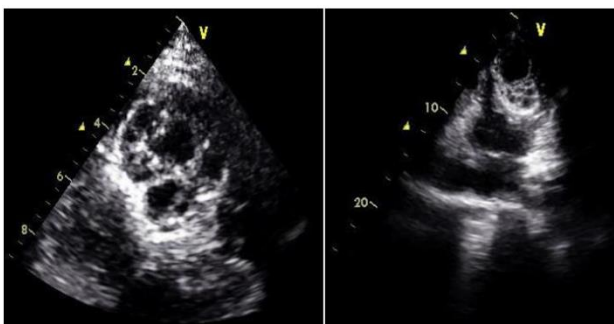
Transthoracic echocardiographic images showing large septated cystic mass in left ventricular apex.
